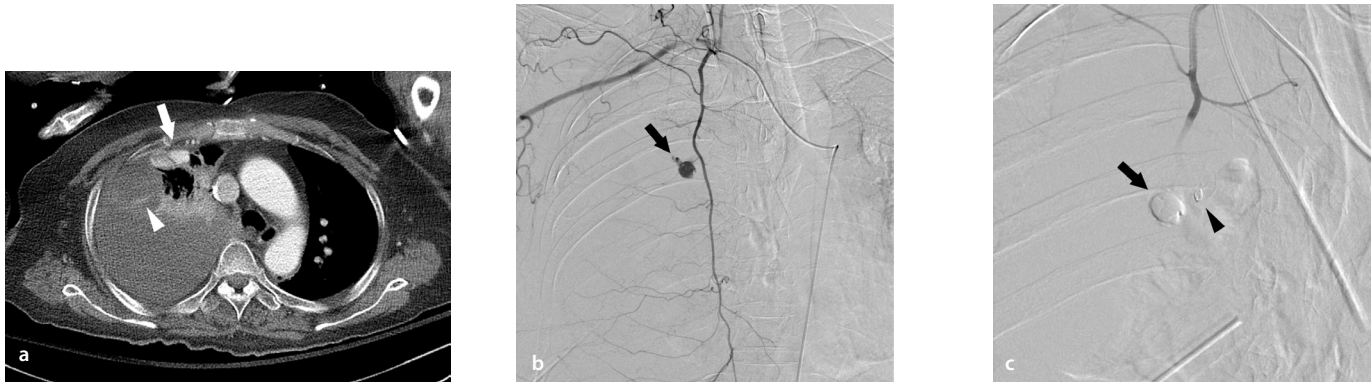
A 64-year-old woman (no: 4) developed a massive hemorrhagic pleural effusion following a percutaneous thoracic needle biopsy (PTNB) for an adenocarcinoma in the right upper lobe. (a) A computed tomography image obtained nine days after a PTNB showing a pseudoaneurysm (arrow) with linear contrast extravasation (arrowhead) from the right internal thoracic artery. (b) The right internal thoracic arteriogram shows a pseudoaneurysm and contrast extravasation (arrow). (c) The right internal thoracic artery distal to the pseudoaneurysm was embolized with one microcoil (arrowhead), and the pseudoaneurysm was embolized with n-butyl-2-cyanoacrylate and gelatin sponge particles (arrow), with no further bleeding.
